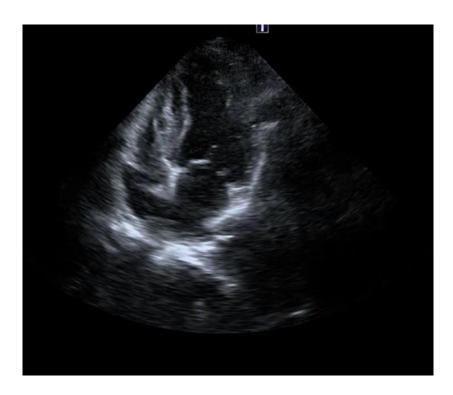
Post PCI Echocardiography
